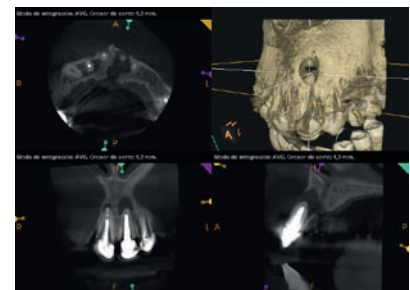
Upper left central incisor preoperative CBCT image. Note the bicortical extension of the lesion and its relation with the nasopalatal canal.
